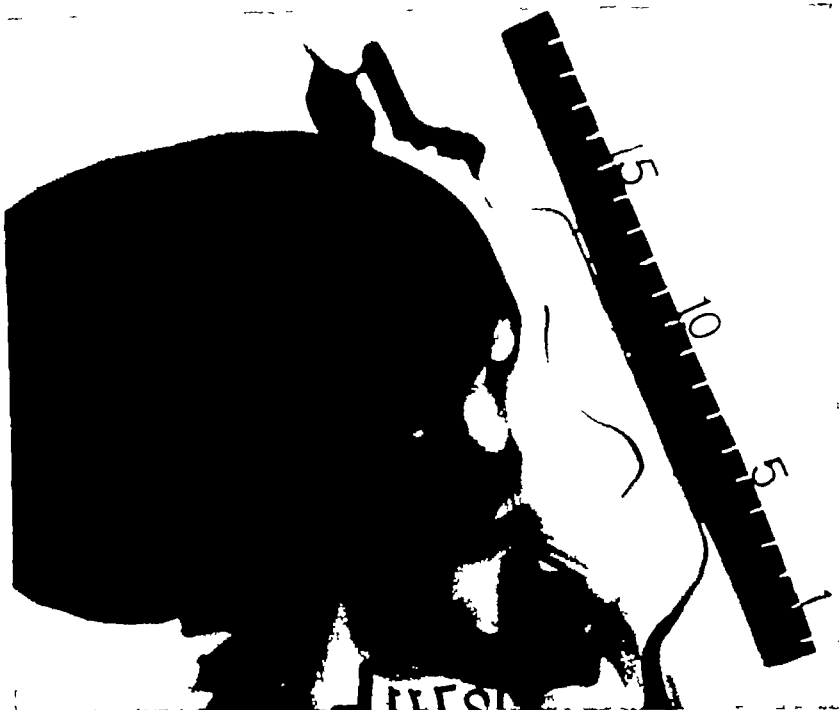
Shows the roentgenogram of the skull with the ruler in position, and lead strip over the nose. The centimeters on the lead ruler and the cranial structures in the mid sagittal plane of the skull show practically the same magnification
